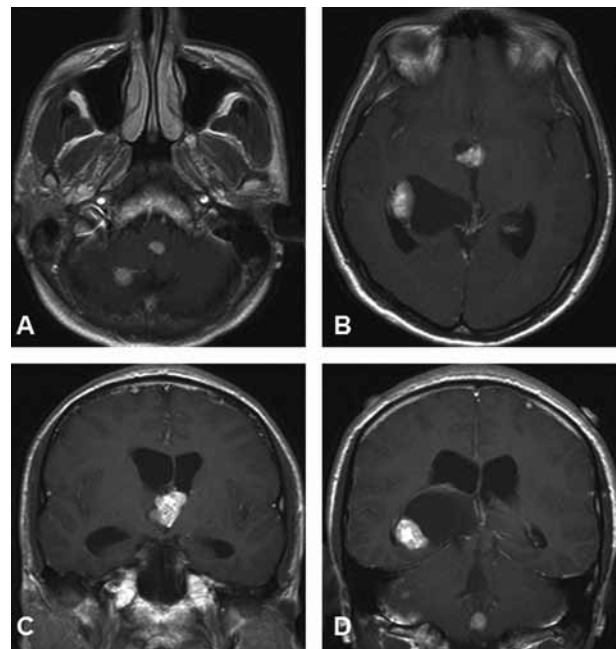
Brain magnetic resonance imaging with gadolinium showing enhanced mass lesions in the third and right lateral ventricles and cerebellum, associated with ventriculomegaly. Note that the lesion in the right lateral ventricle also has a cystic component (A, B: axial view; C, D: coronal view).
